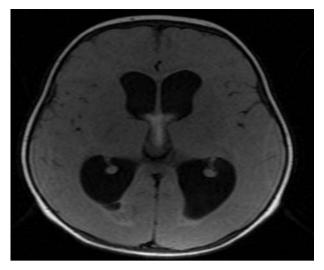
T2 coronal MRI brain- depicting dilated lateral ventricles.
